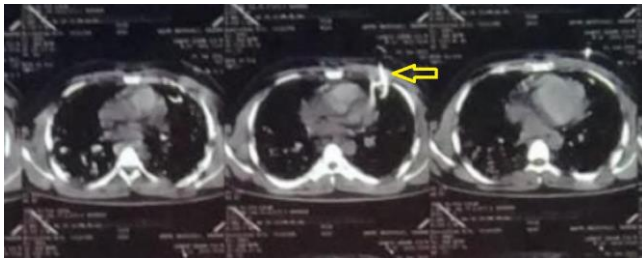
HRCT image of the patient with a pigtail catheter in the mediastinum (yellow arrow)
